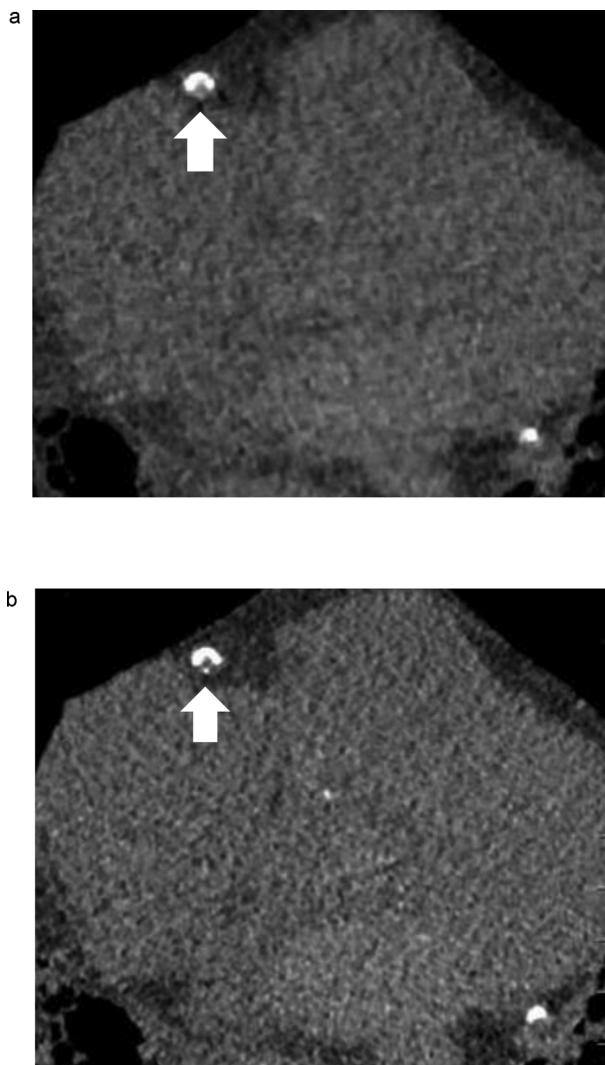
CT images of the right coronary artery in an 83-year-old male corpse. The scans were obtained in (a) NR- and (b) in SHR mode. On the scan obtained in SHR mode, small spotty calcifications are clearly identified (arrows).
